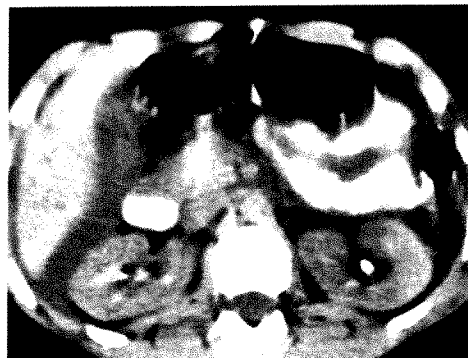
CT scans show free fluid and thickened bowel loops in a 14-year-old girl who was involved in a motor vehicle accident while wearing a seat belt. Because of high suspicion of bowel injury, CT with oral contrast medium was performed with patient in supine and in lateral decubitus positions. No evidence of extravasation of contrast material or pneumoperitoneum was seen. Upper gastrointestinal series done again next day was normal. On third day, because symptoms continued to worsen, patient was taken to surgery. A jejunal perforation 30 cm distal to ligament of Treitz was found.
